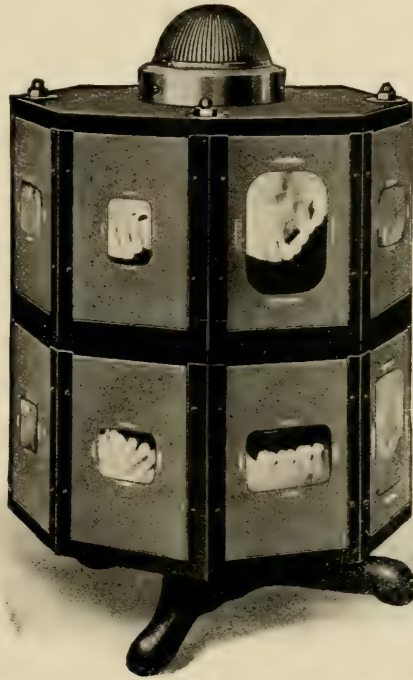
Special dental illuminating device for displaying and observing dental X-ray negatives.
